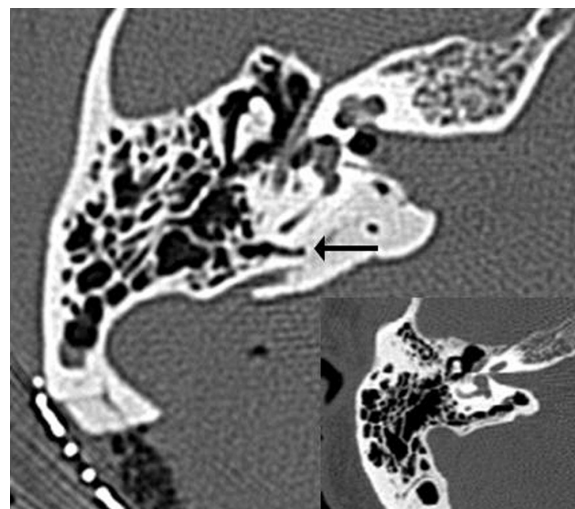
Temporal bone CT scan showing the HAC cement reconstruction of the posterior wall of the porus with occlusion of an exposed air cell (arrow). Inset: The posterior wall of a different porus acusticus with well-pneumatized bone highlighting the susceptibility to CSF fistula formation if not occluded after drilling.
